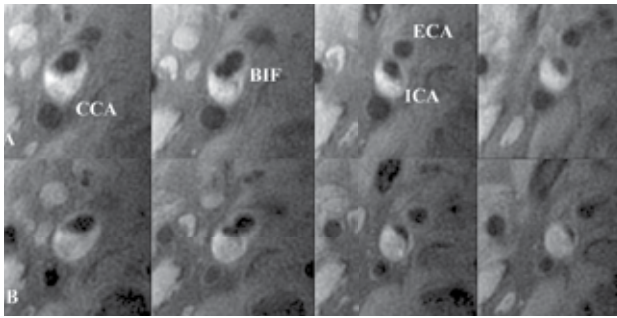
T1-weighted images of progression of atherosclerosis associated with intraplaque hemorrhage in the right carotid artery. Each column presents matched cross-sectional locations in carotid artery from baseline MRI (A) and MRI obtained 18 months later (B). Lumen area was decreased, and wall area was increased in each location on the second examination. CCA = common carotid artery; BIF = common carotid bifurcation; ICA = internal carotid artery; and ECA = external carotid artery.
